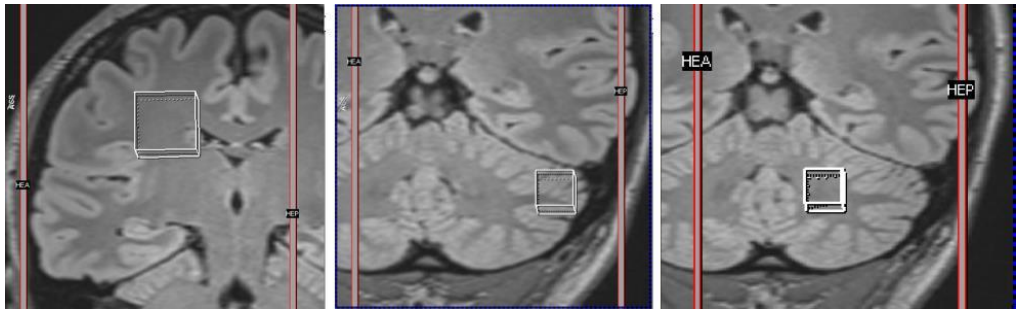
Localization of MRS volumes of interest (VOIs). Coronal sections of T1-weighted images from a representative subject for VOIs localization. From left to right: VOI in the WM of the right cerebral hemisphere ($2 \times 2 \times 2 \text{ cm}^3$, used as reference region), VOI in the left cerebellar GM (Crus I-II), and VOI in the left cerebellar WM (both $1.5 \times 1.5 \times 1.5 \text{ cm}^3$).
